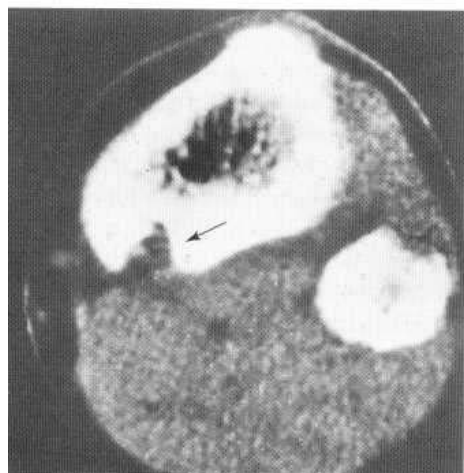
Fibrous cortical defect in the upper medial tibia is shown on CT (arrow). Note the purely cortical position of the defect and its sharply defined margin. The thin shell of overlying bone is not seen completely because of the partial volume effect.
